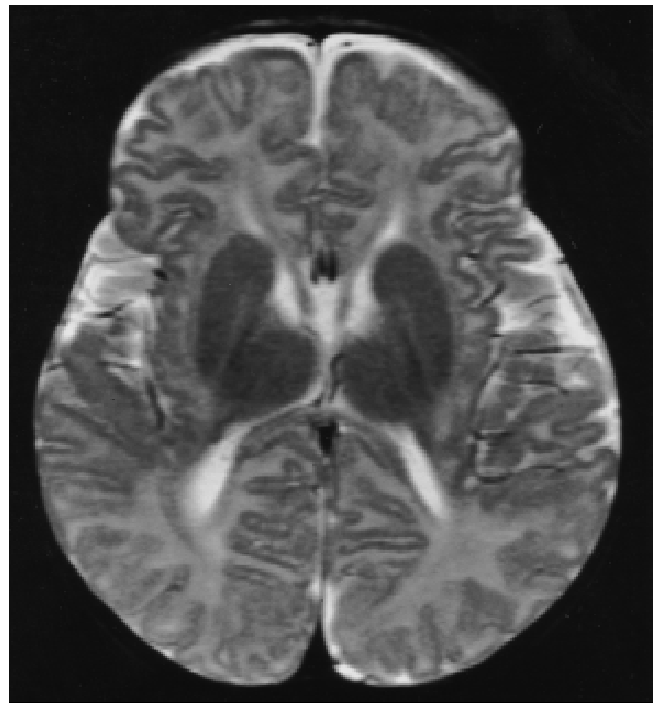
Patient 1: head MRI showing megalencephaly.
